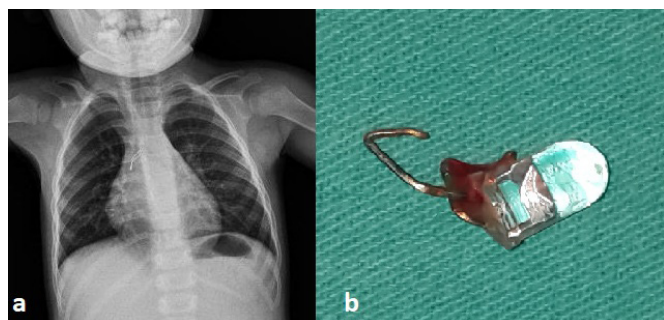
(a) Foreign body with the appearance of 2 wires in PA chest x-ray, (b) removed LED of remote control.
